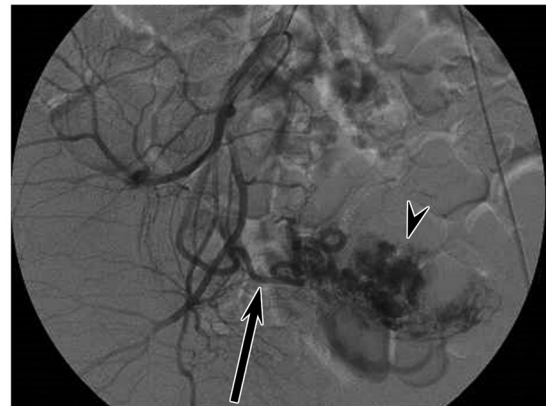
RPOC in a 33-year-old woman. (a) Sagittal T2-weighted MR image shows a hyperintense polypoid mass (arrow) in the endometrial cavity and a hypointense area around the mass. (b) Sagittal contrast-enhanced T1-weighted MR image shows marked enhancement of the mass (arrow) protruding into the endometrial cavity. (c) Right internal iliac arteriogram shows a dilated right uterine artery (arrow) and a hypervascular mass (arrowhead). Bilateral uterine artery embolization was performed before hysteroscopic resection, which confirmed the diagnosis.
